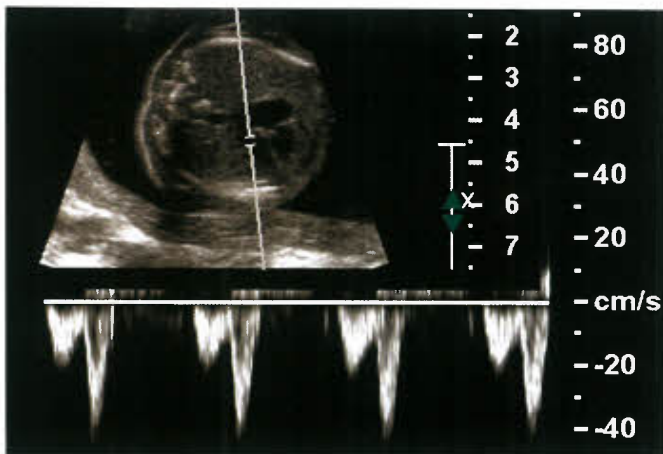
Fetal inflow pattern. A typical mitral inflow pattern on a fetal exam obtained from an apical four-chamber view with $E < A$ and prolonged IRTs.
